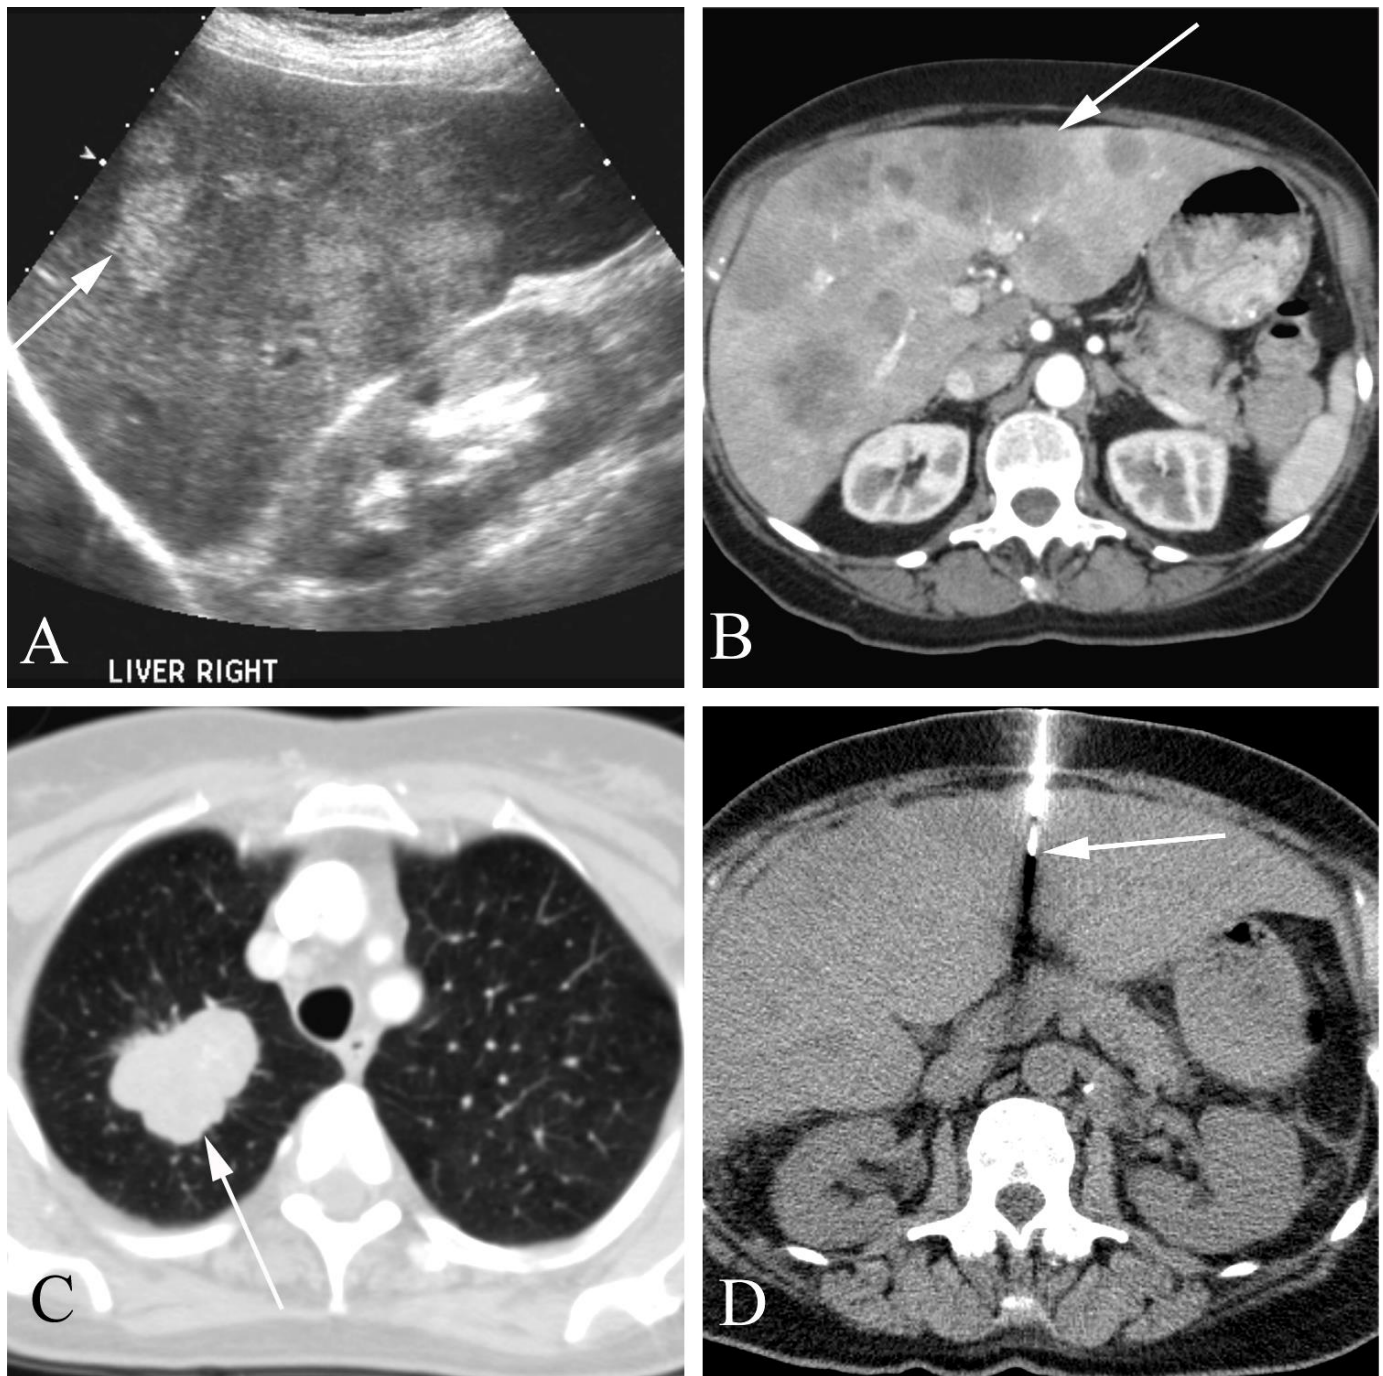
Metastatic liver disease in a 66 year old woman with abnormal liver function tests (elevation of AST, ALT, alkaline phosphatase, and GGT). A. The hepatobiliary ultrasound shows multiple, hyperechoic lesions scattered through the liver (arrow). B. The CT scan of the abdomen confirmed multiple liver lesions (arrow). C. The chest CT, done at the same time as the abdominal CT for tumor evaluation, demonstrates a tumor of the right upper lobe (arrow). D. CT-directed biopsy shows the needle tip in the left lobe of the liver, at the location of the lesion seen on the contrast-enhanced exam (arrow). As no contrast was given, the liver lesions are much less conspicuous on this study. Biopsy results indicated a metastatic lung tumor.
